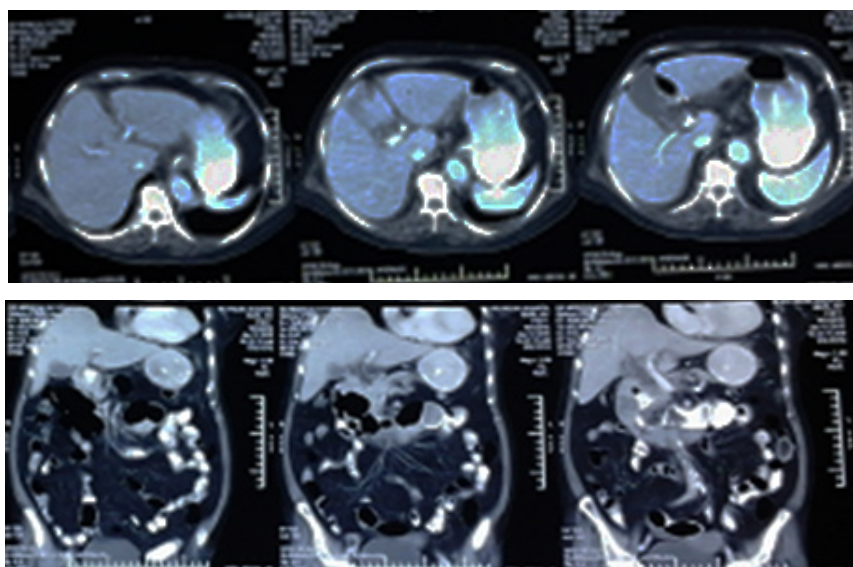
Abdominal CT scan showed thickening wall of the pylorus (1.28 cm) and duodenal wall at second part and third part (approximately: 2.32 cm) suspected was an intraluminal mass, widening CBD (13.6 mm) and pancreatic duct (2,8mm); simple cyst in the upper pole of the right kidney (8 mm), multiple cysts in the lower pole of the left kidney (the largest size of 1.44 cm), and aortic calcification
